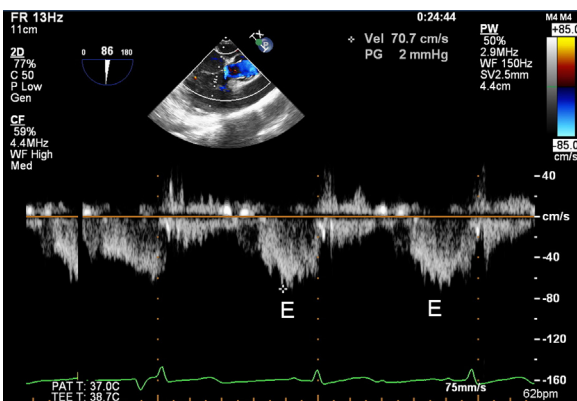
Tricuspid inflow velocity in the inflow-outflow view. Pulsed-wave Doppler spectral velocity of TV inflow depicting a peak velocity 70.7 cm/s. The TV inflow velocity was not accelerated despite severe compression by the giant RA diverticulum. There was no clear evidence of a late diastolic A wave (E, early diastolic rapid filling velocity; TV, tricuspid valve; RA, right atrium).
